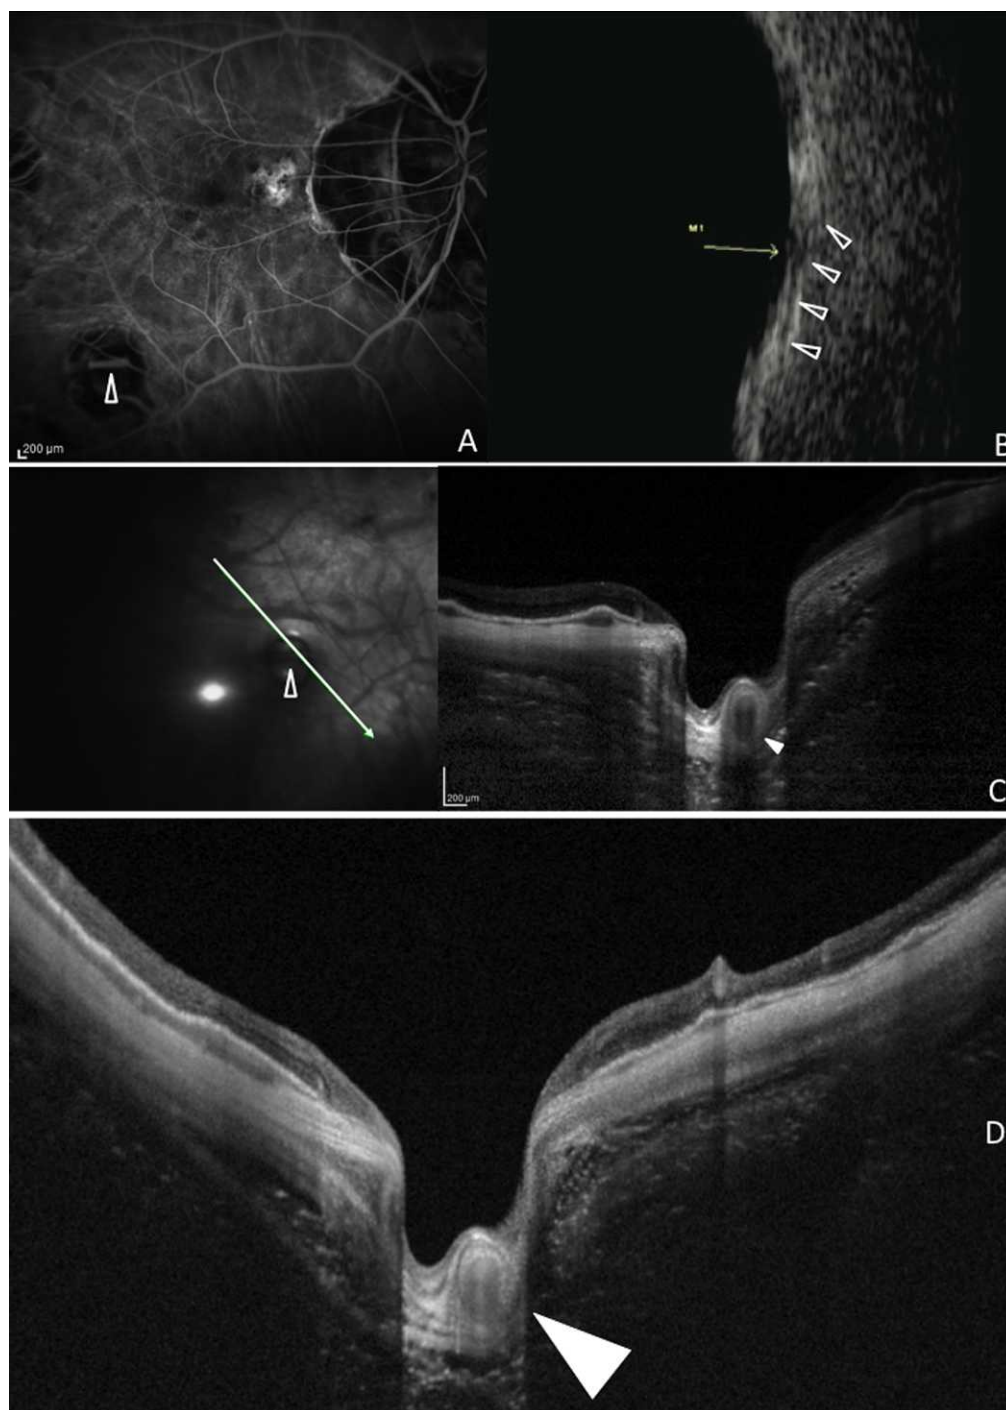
Fluorescein angiography ultrasonography, EDI-OCT, and SS-OCT of a 60-year-old woman with high myopia. Fluorescein angiography: a crossing vessel is visible through the atrophic lesion ([A], *open arrowhead*). Ultrasonography shows a vessel coming from the retrobulbar space, and running through the sclera ([B], *open arrowhead*), after being perforated in correspondence of the focal ectasia ([B], *thin arrow*). EDI-OCT (C) and SS-OCT (D) show a cross-section of the perforating vessel at the bottom of the ectasia (*arrowheads*).
